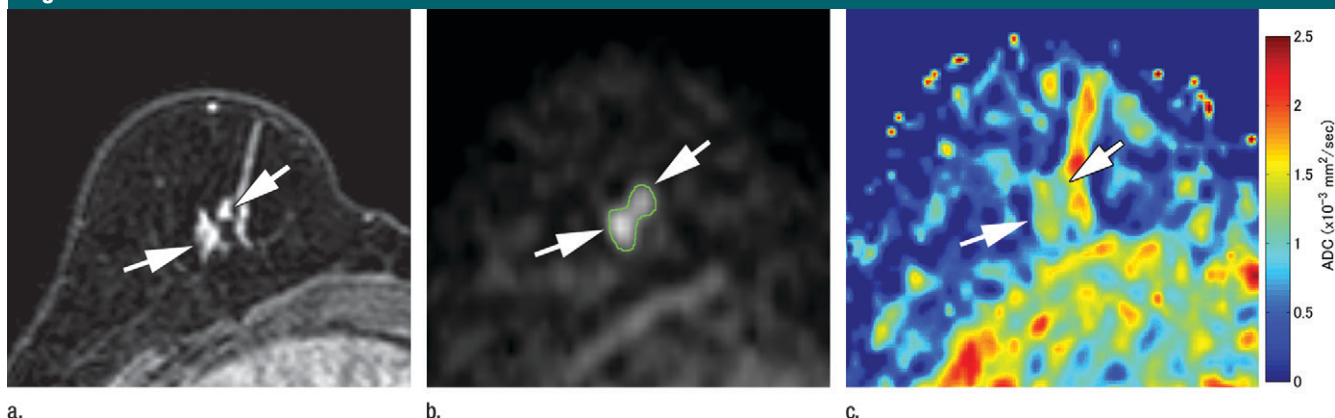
High-grade DCIS in a 56-year-old woman. (a) Dynamic contrast-enhanced MR image obtained in early phase, (b) diffusion-weighted MR image ($b = 1000 \text{ sec/mm}^2$), and (c) ADC map. (a) Areas of homogeneous nonmasslike enhancement (arrows) are shown; this image was used to identify lesions and define corresponding ROIs on b (arrows), where lesions are visible as areas of high signal intensity. (c) Lesion exhibits areas with light blue contours (arrows), which are indicative of low ADC.
